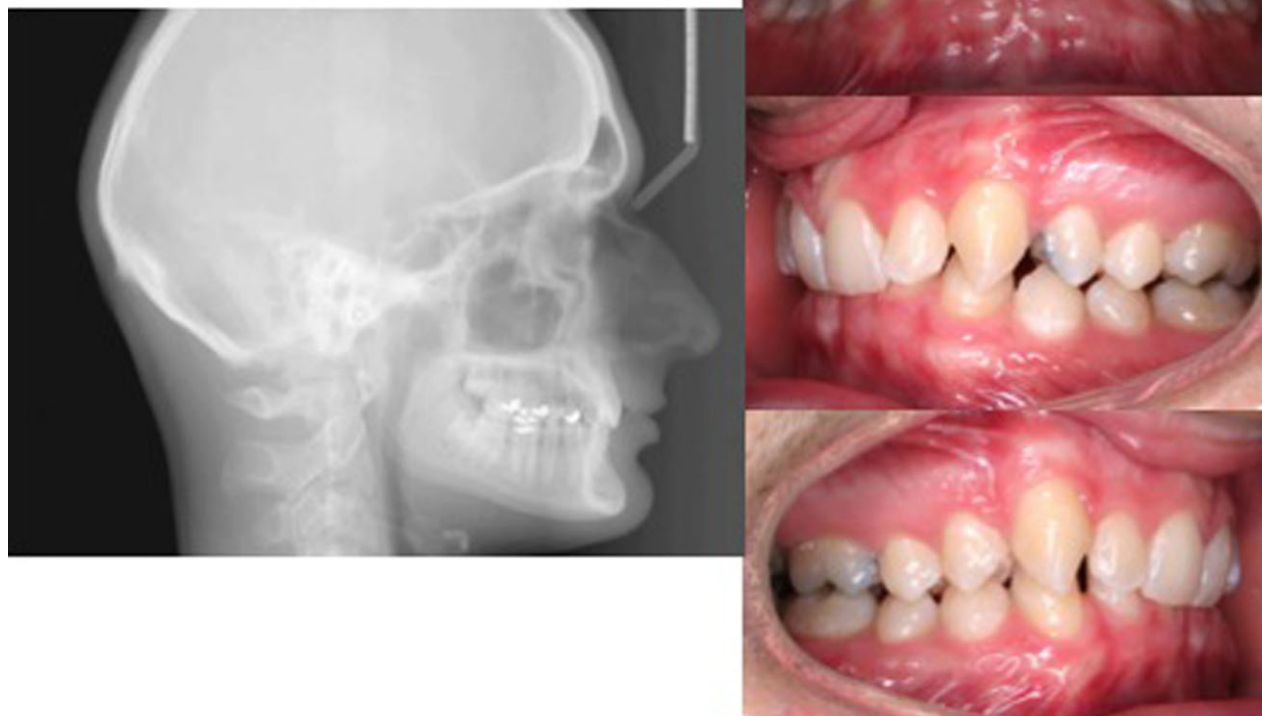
Pretreatment records. The lateral cephalometric radiograph and clinical intraoral photographs depict a 'routine' Class II Division II appearance. The patient has a 100% overbite and approximately one-half cusp Class II relationship of the buccal segment.
